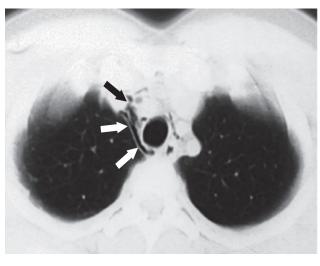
Case 3: a single HRCT cut showing mediastinal emphysema
